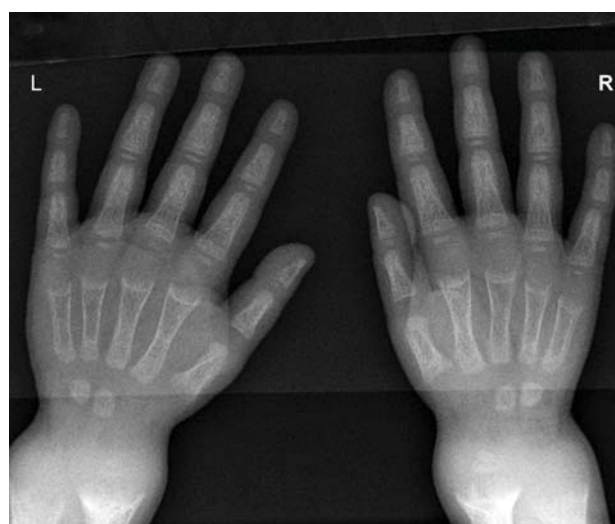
X-ray changes at wrist in rickets.
